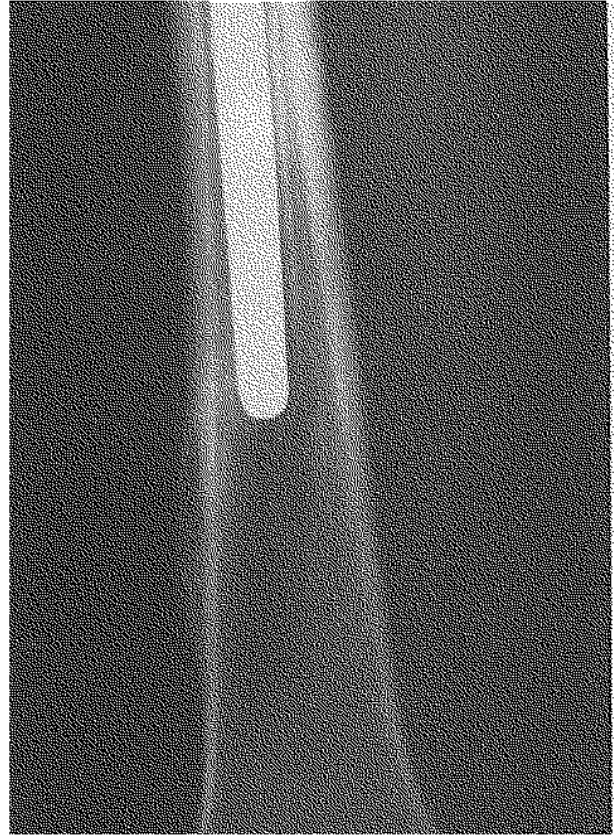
Xray two years postoperatively.
